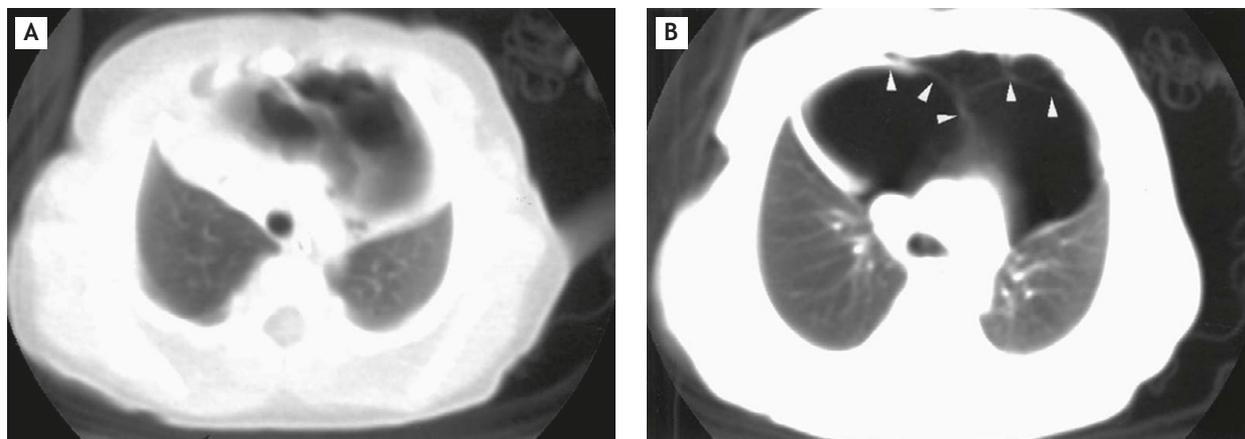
Postcontrast chest computed tomography at 3 days old. The upper portion (A) and the lower portion (B) of the cyst. Note the thin septum within the cyst (arrowhead).
